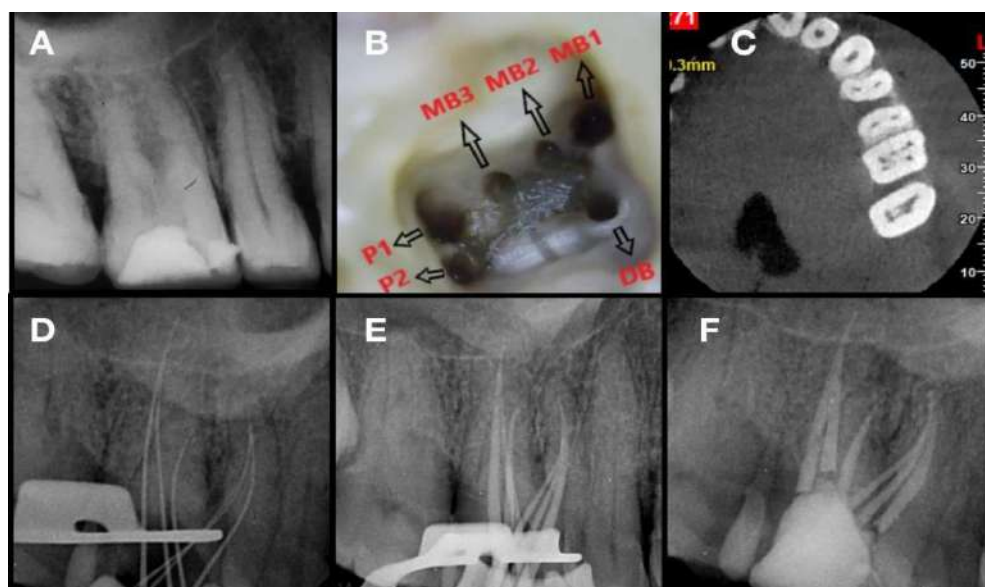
A- Preoperative radiograph; B- Access opening showing three mesiobuccal (MB1, MB2 and MB3), two palatal (P1 and P2) and one distobuccal (DB) canal orifices; C- CBCT image; D- Working Length radiograph; E- Master cone radiograph; F- Obturation radiograph
